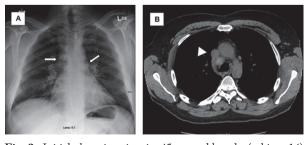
Initial chest imaging in 45-year old male (subject 14) subsequently diagnosed with cardiac sarcoidosis. A. Chest x-ray showing hilar lymphadenopathy (white arrows). B. Computed tomography of the chest showing documenting hilar and mediastinal lymphadenopathy (white arrow head).
